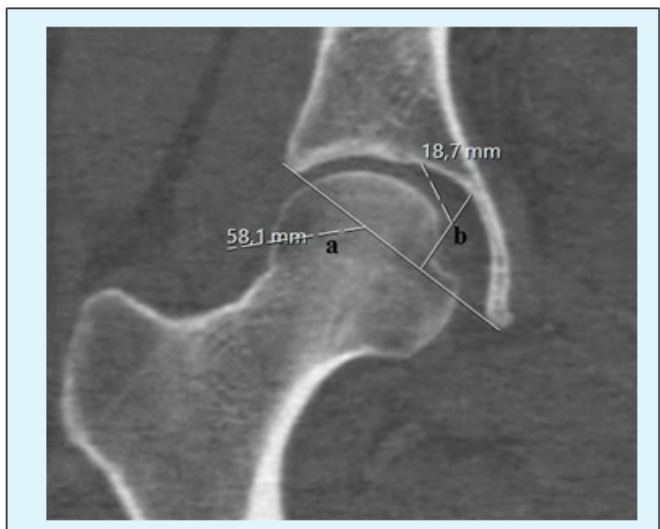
Measurements over CT; a: AD, b: Depth.
